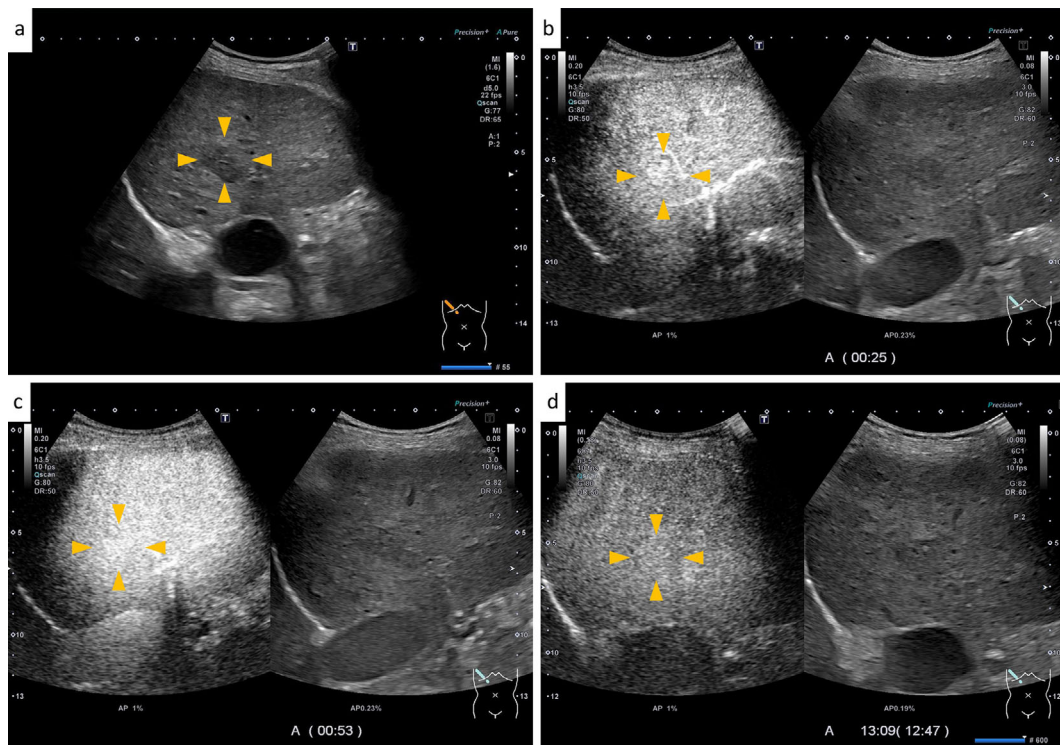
Abdominal ultrasonography imaging. (a) B-mode imaging showed multiple low-echoic masses. (b-d) Contrast-enhanced ultrasonography showed enhancement in the arterial phase and sustained enhancement in the portal and post-vascular phases.
